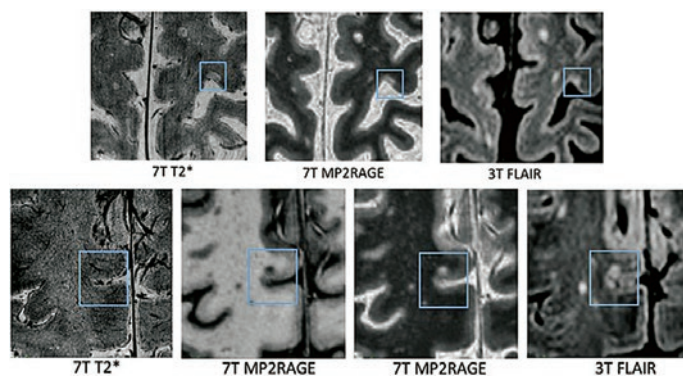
Presentation of cortical lesions detected by imaging on 3T and 7T MRI
